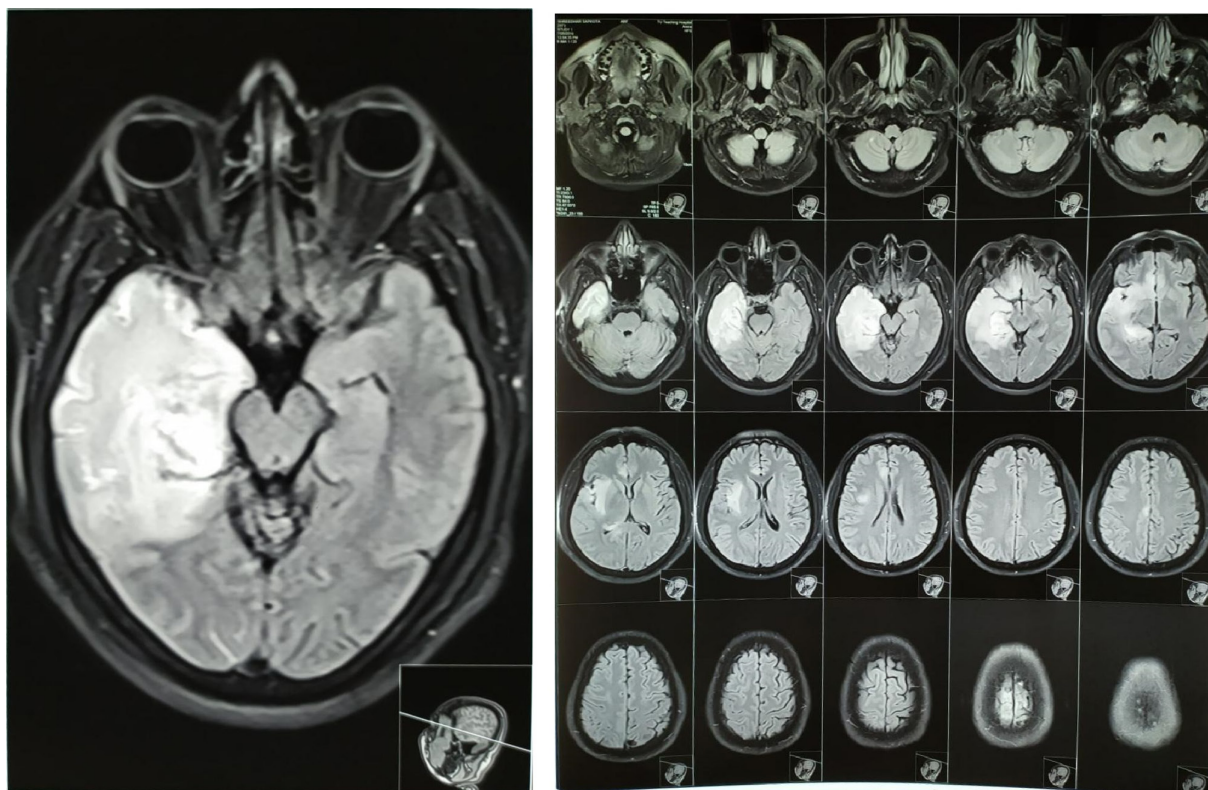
Initial T2-FLAIR fat suppressed MRI brain showing right temporal lobe enhancement without any signs of hemorrhage.
